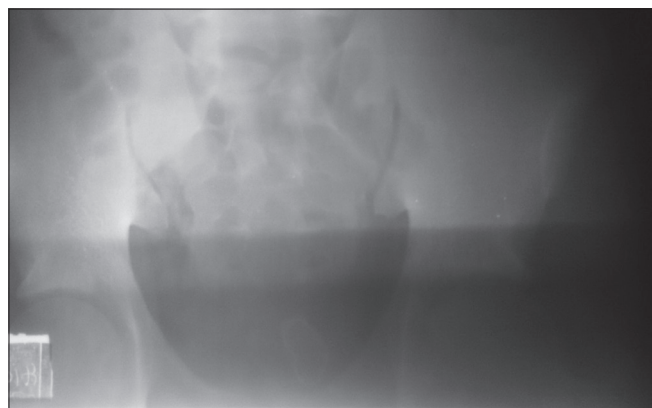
Plain abdominal X-ray showing foreign body in the bladder
